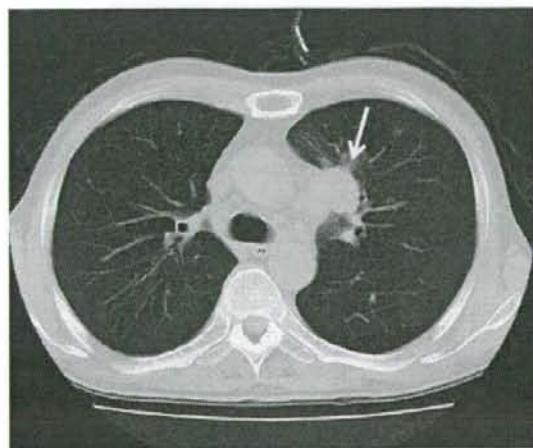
CT scan of the lung before treatment. A nodule of 3 cm in diameter in the left inferior segment (S3) of the upper lobe is shown
